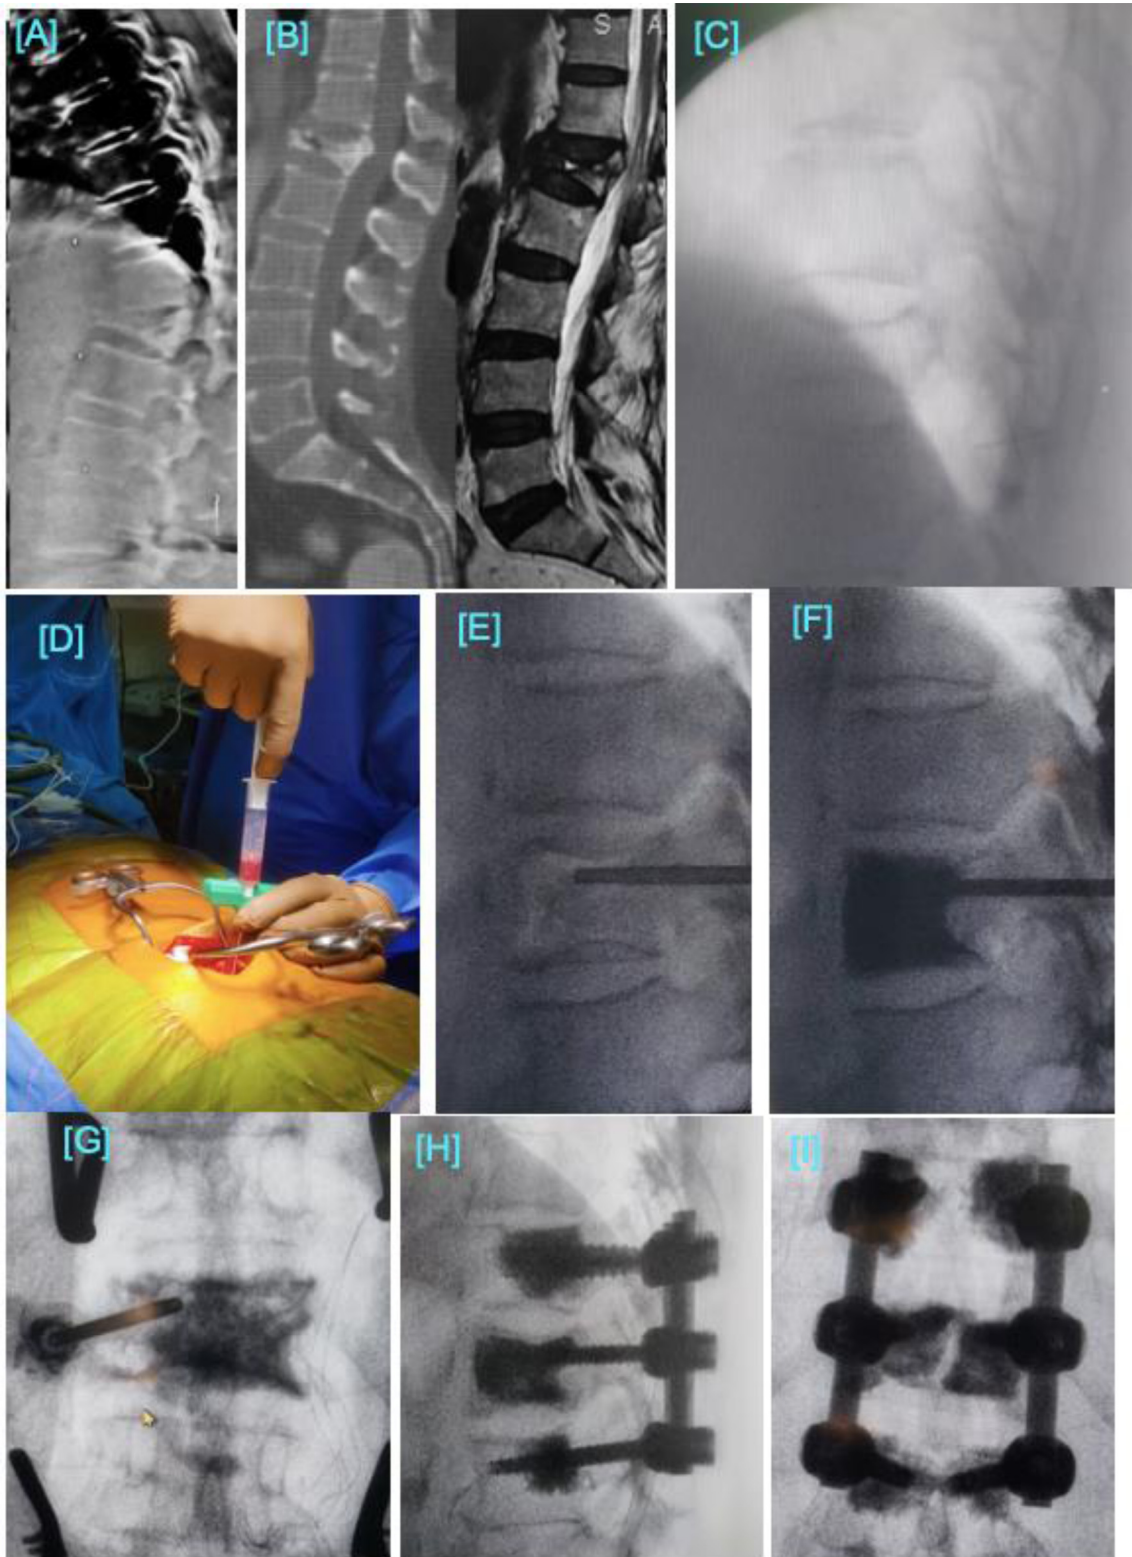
72-year-old female patient with D12 osteoporotic burst fracture underwent vertebroplasty with cement augmented pedicle screws short segment fixation. [A,B] The preoperative lateral radiograph, sagittal CT scan showed L1 osteoporotic vertebral fracture with fluid collection on MRI. [C] Radiograph showing correction and partial restoration of vertebral height after prone position on operation table. [D] intraoperative aspiration on fluid from non-united osteoporotic vertebral fracture. [E] Radiograph after aspiration of fluid. [F,G] Vertebrogram. [H,I] Postoperative radiogram showing vertebroplasty with short segment fixation with restoration of vertebral height.
